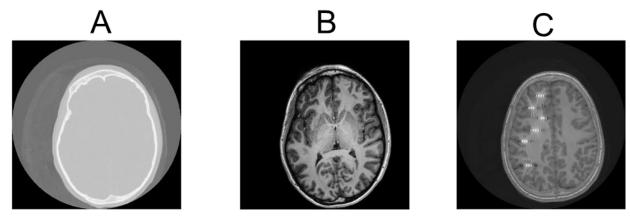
Coregister MRI and CT scans. (A) Axial view of a typical CT scan. (B) Axial view of a typical MRI scan. (C) Coregistered MRI and CT scans, electrode contacts are visible as bright dots inside the brain structure.
